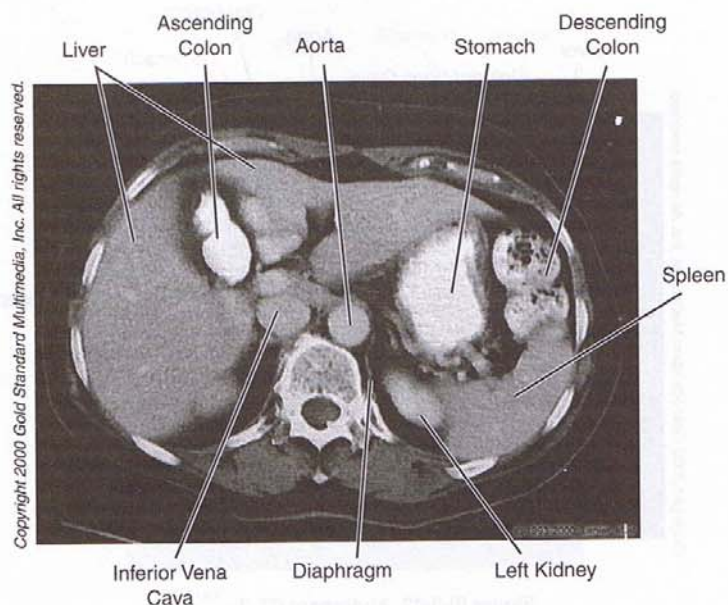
Abdomen: CT, T₁₂
